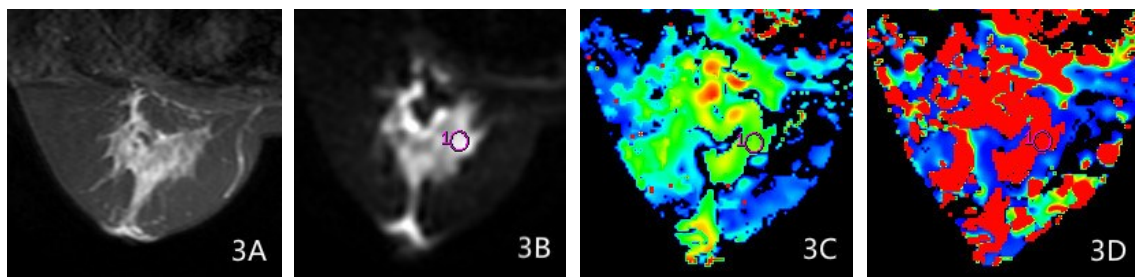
The images of MRI scanning for patients with grade III breast cancer. Forty-two years old female patients with left breast invasive cancer at grade III. (3A) T2WI sequence of fat suppression. (3B) The corresponding gray-scale image when selecting ROI. (3C, 3D) The IVIM parameters of this patient: $D\text{-mono} = 0.00092$; $D^*\text{-mono} = 0.02355$; $f\text{-mono} = 0.30889$; $D\text{-bi} = 0.00028$; $D^*\text{-bi} = 0.13884$; $f\text{-bi} = 0.32264$.
